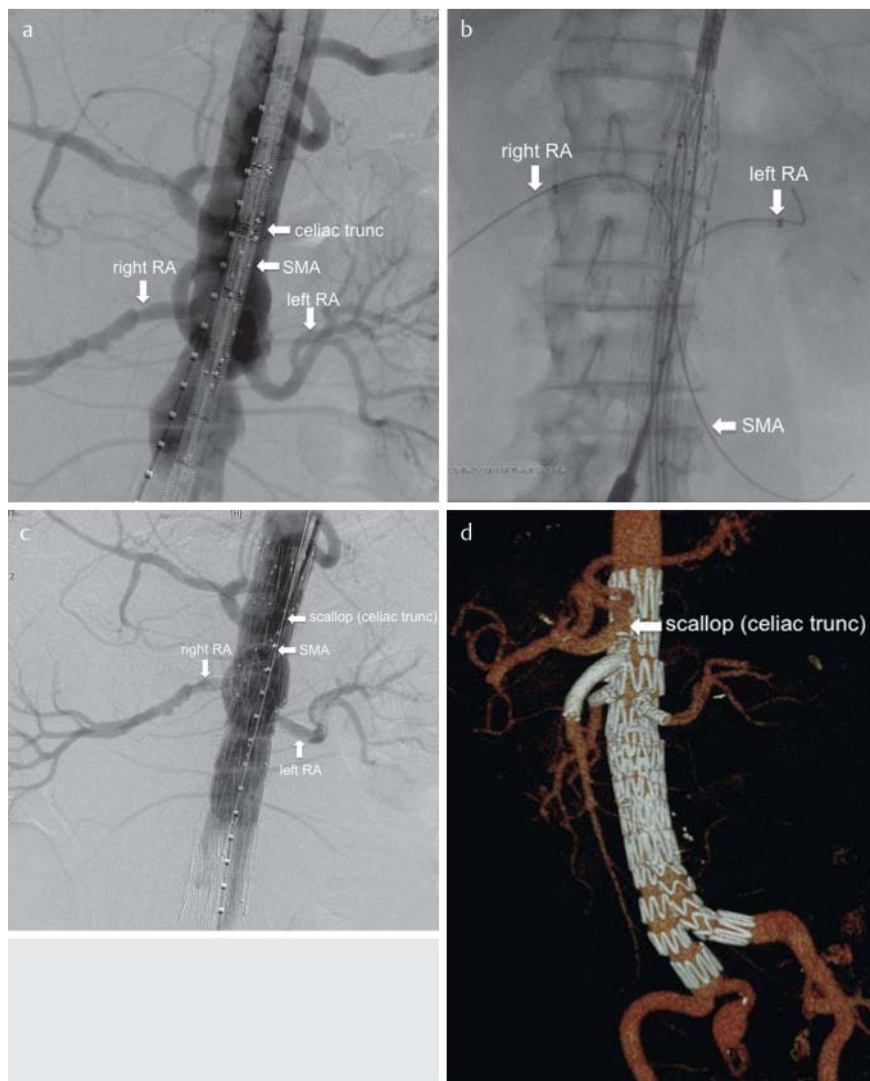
a–d Fenestrated grafts (fEVAR). 64-year-old male patient with juxtarenal AAA and a maximum diameter of 56 mm. The initial angiogram a shows the pararenal aneurysm including the origins of the visceral arteries. After placement of the fenestrated aortic stent graft, the visceral arteries were catheterized via a femoral access and sheaths were placed into superior mesenteric and both renal arteries to allow an exact deployment of the fenestrated graft b. After final deployment of the fenestrated graft, the covered stents (Advanta V12, Atrium Europe, SL Mijdrecht, The Netherlands) were implanted and flaired inside the aorta to improve the seal and to avoid endoleaks. The perfusion of the celiac trunk is established by a scallop c. The final angiogram c and the postinterventional CTA-VRT d shows no endoleak and good perfusion of the visceral arteries via three fenestrations and one scallop (celiac trunk).
